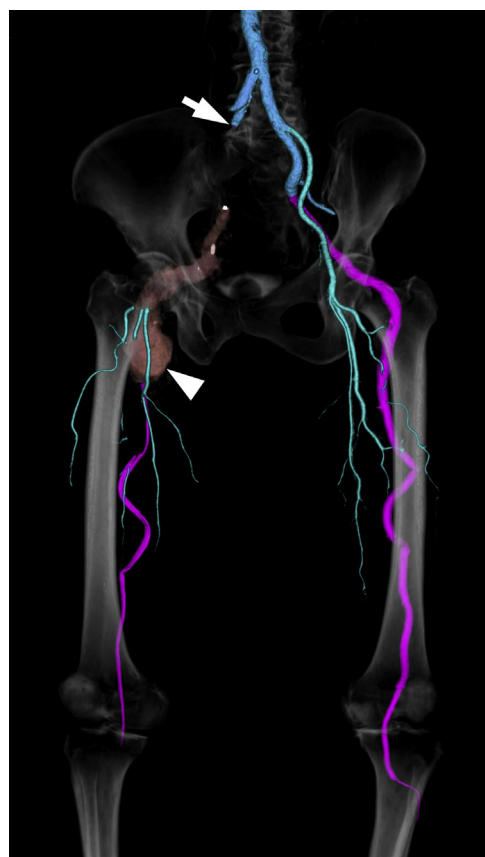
Initial three-dimensional computed tomography angiogram showing a bilateral persistent sciatic artery (PSA). Continuous thrombotic occlusion is observed extending from the orifice of the right internal iliac artery (IIA; *arrow*) to the end of the PSA aneurysm (PSAA; *arrowhead*) and extending from the orifice of the external iliac artery (EIA) to the proximal part of the deep femoral artery. Intermittent thrombosis is observed extending from the distal end of the PSAA to the below-the-knee popliteal artery.
